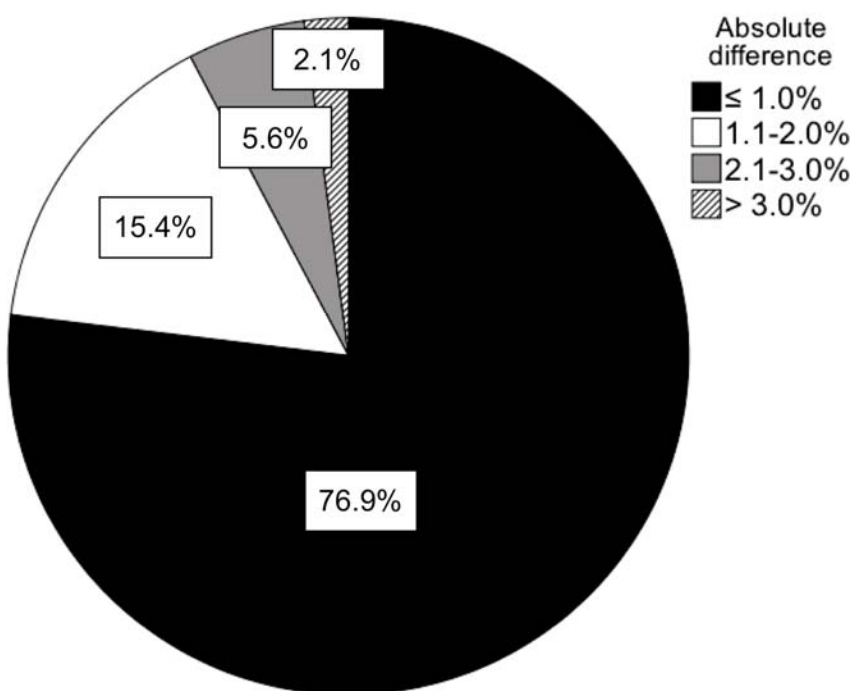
Absolute differences for interobserver measurements of total lung (A) and lobar (B) contribution using SPECT/CT.
